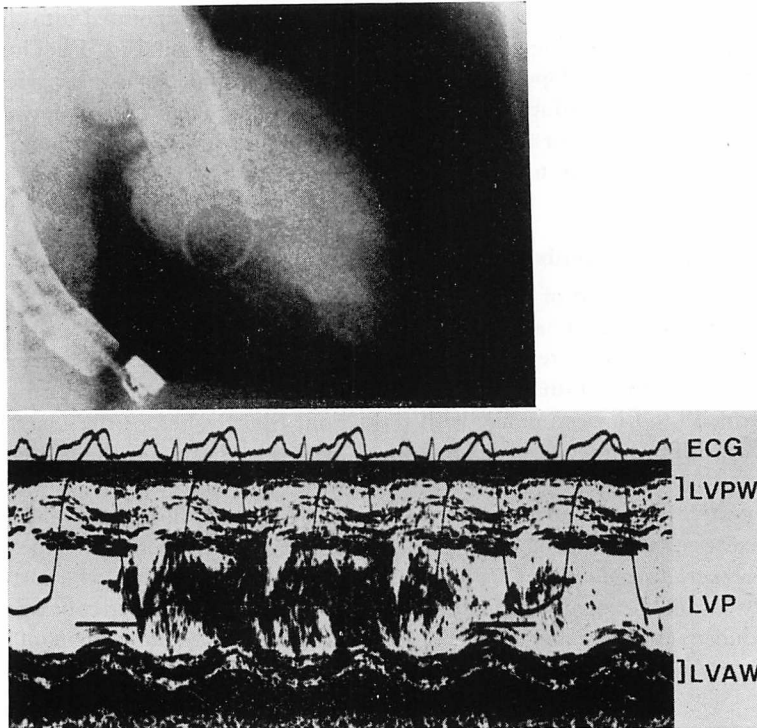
The spatial relationship of the transesophageal echo probe against the left ventricle and the transesophageal echocardiographic identification of the left ventricle.
